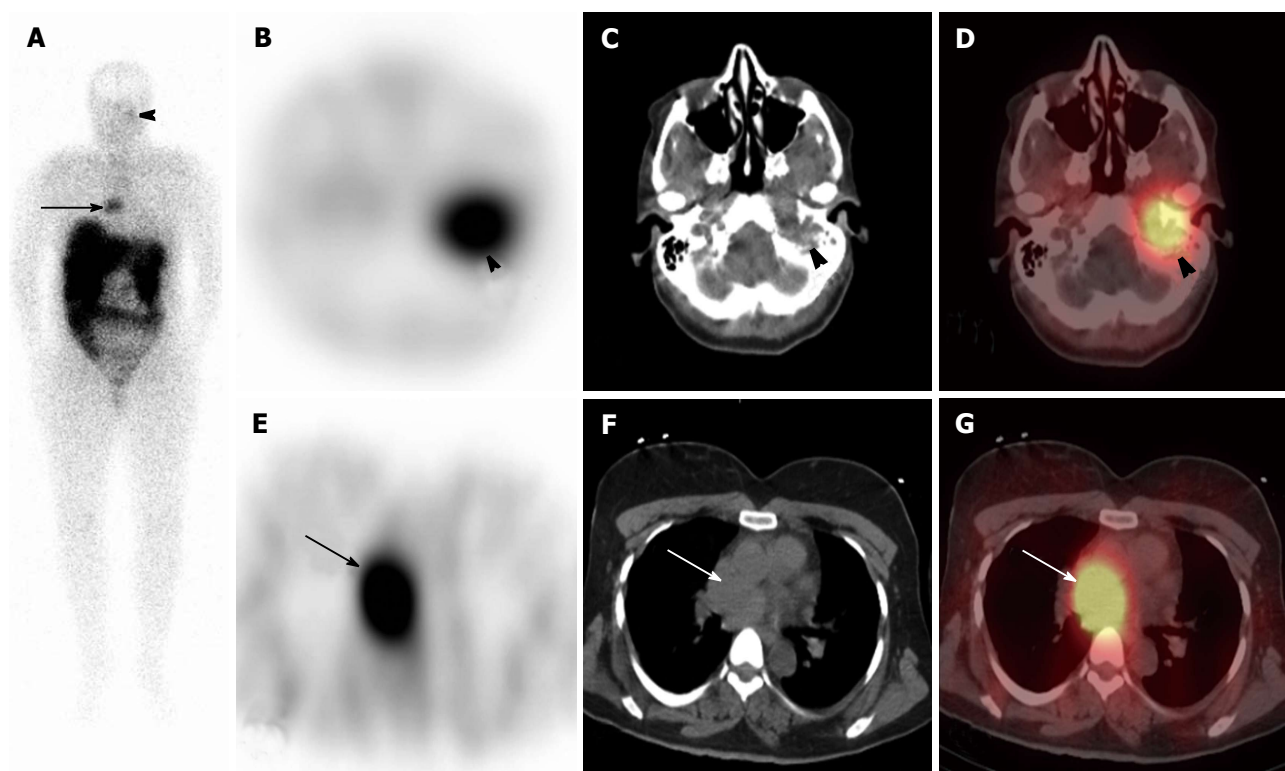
^{111}In -DTPA-pentetreotide scan in a 45-year-old woman with paraganglioma and glomus tumor, to evaluate for octreotide-avidity. On anterior (A) whole body planar images, there are 2 foci of uptake overlying the left skull base (arrowhead) and the mediastinum (arrows). On Axial SPECT, CT and SPECT/CT (B-D) the skull base radiotracer uptake localizes to a known glomus jugulare tumor adjacent to the left temporal bone and on thoracic axial SPECT, CT and SPECT/CT (E-G) the thoracic radioactivity is within a soft tissue mass in the middle mediastinum, located posterior to the ascending aorta. There is no abnormal radiotracer accumulation below the diaphragm. SPECT: Single photon emission computed tomography; CT: Computed tomography.
